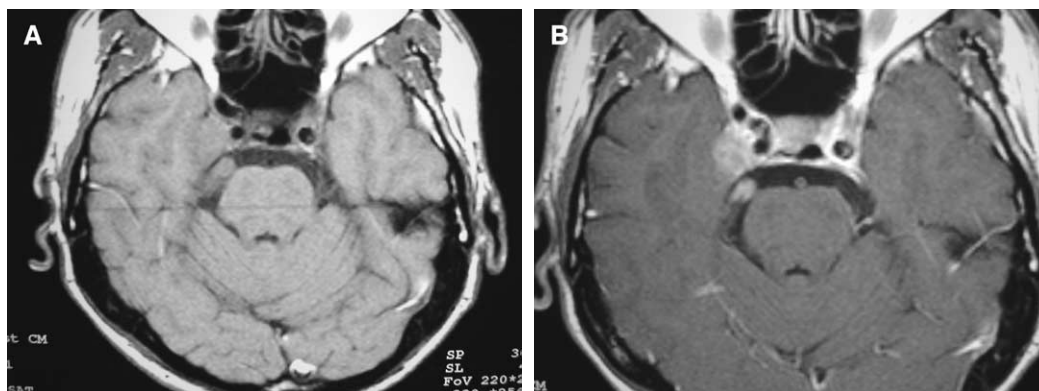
Right parasellar fifth nerve schwannoma. (A) Axial T1-weighted image shows an isointense mass involving the right cavernous sinus and along the right fifth cranial nerve. (B) Axial postcontrast image shows enhancement of the mass lesion.
